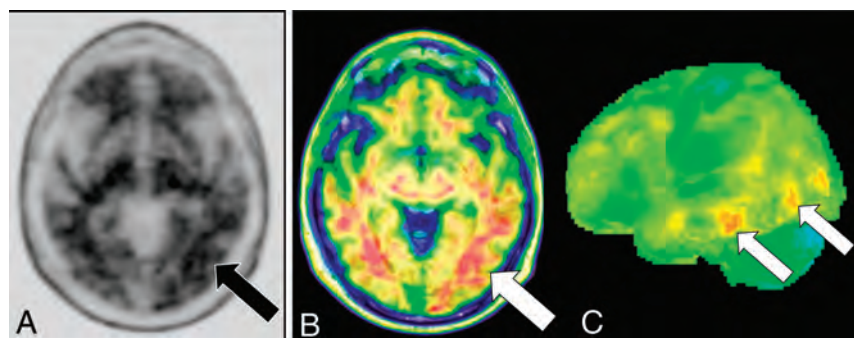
[^{18}F] florbetaben PET axial gray-scale (A), axial color map fused to a T1-weighted MR image (B), and left lateral 3D stereotactic surface projection (C) demonstrate focal areas of increased cortical β -amyloid deposition in the left temporal lobe (arrows).
